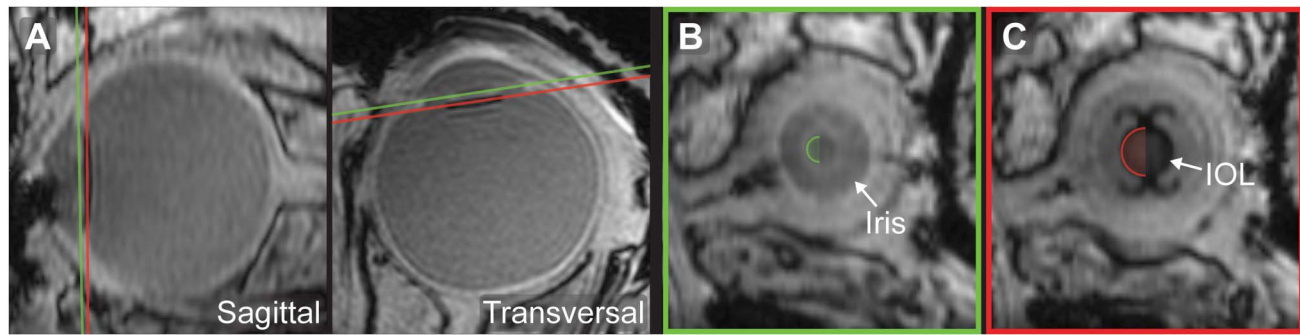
Example of the determination of the geometrical relation between the iris and the IOL using the 3DT1 MR images. A: The multiplanar reconstruction planes defined through the iris (green line) and through the IOL (red line) on sagittal and transversal views. B: The reconstructed image of the iris with a manual annotation of the pupil by a best-fit circle (green semicircle). C: The reconstructed view of the IOL with a manual annotation of the IOL optic by a best-fit circle (red semicircle).
